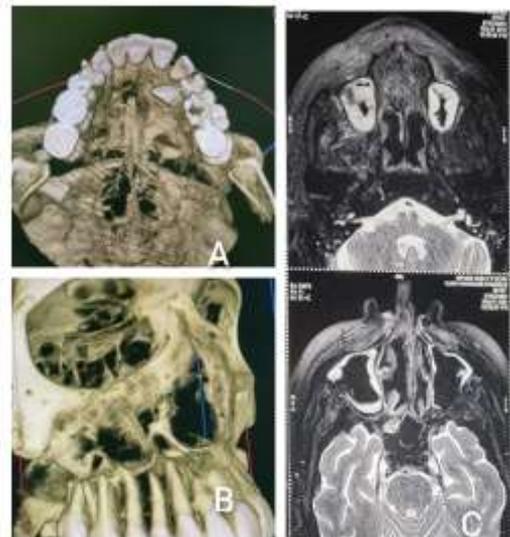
MRI and CBCT showing recurrent disease.
